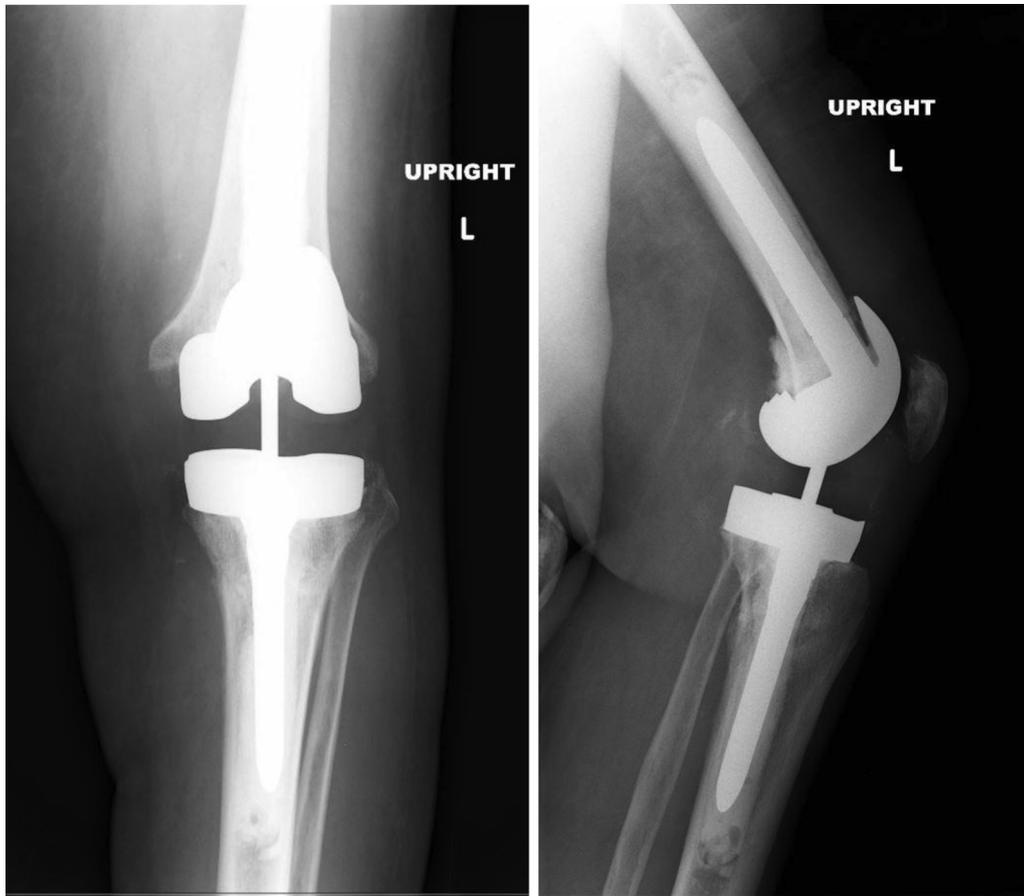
Post-operative left TKA revision radiographs.
